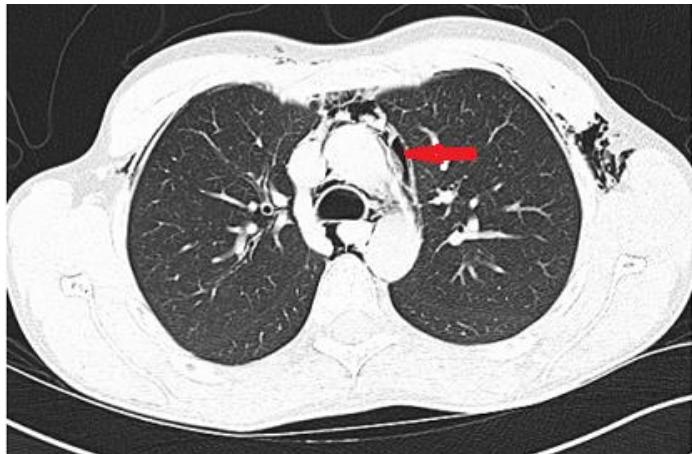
Computed tomography of the thorax showing subcutaneous emphysema and pneumomediastinum (red arrow).
